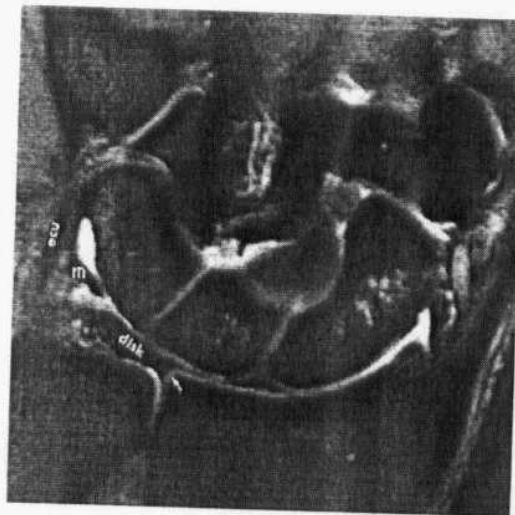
Fat-suppressed T2-weighted fast spin-echo coronal image of the normal TFCC. The biconcave central disk (disk), extensor carpi ulnaris (ecu), meniscal homologue (m), and cartilage of the radial sigmoid notch (arrow) are identified (Quoted from stoller and Brody, 1997).
